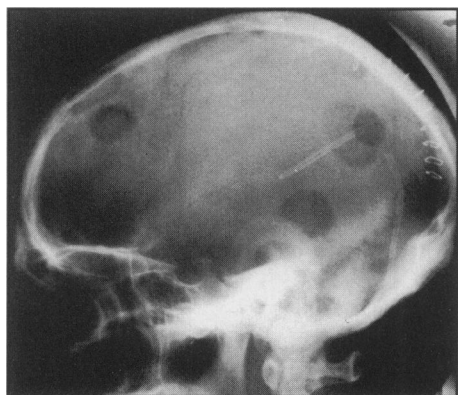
Lateral Skull X-Ray
